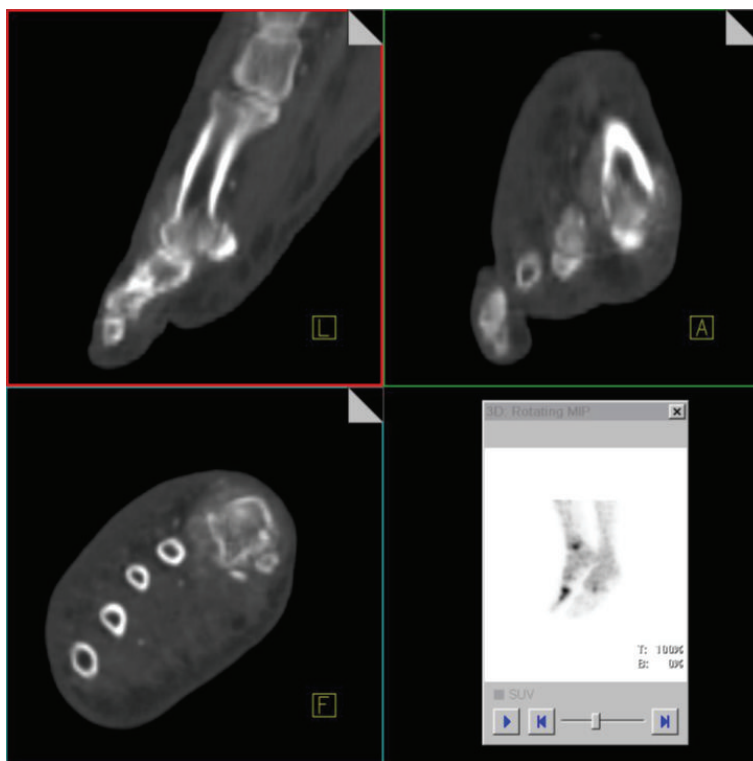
CT-data of the combined SPECT/CT demonstrates soft tissue and periosteal reaction and mild osseous disruptions at the MTP I.
